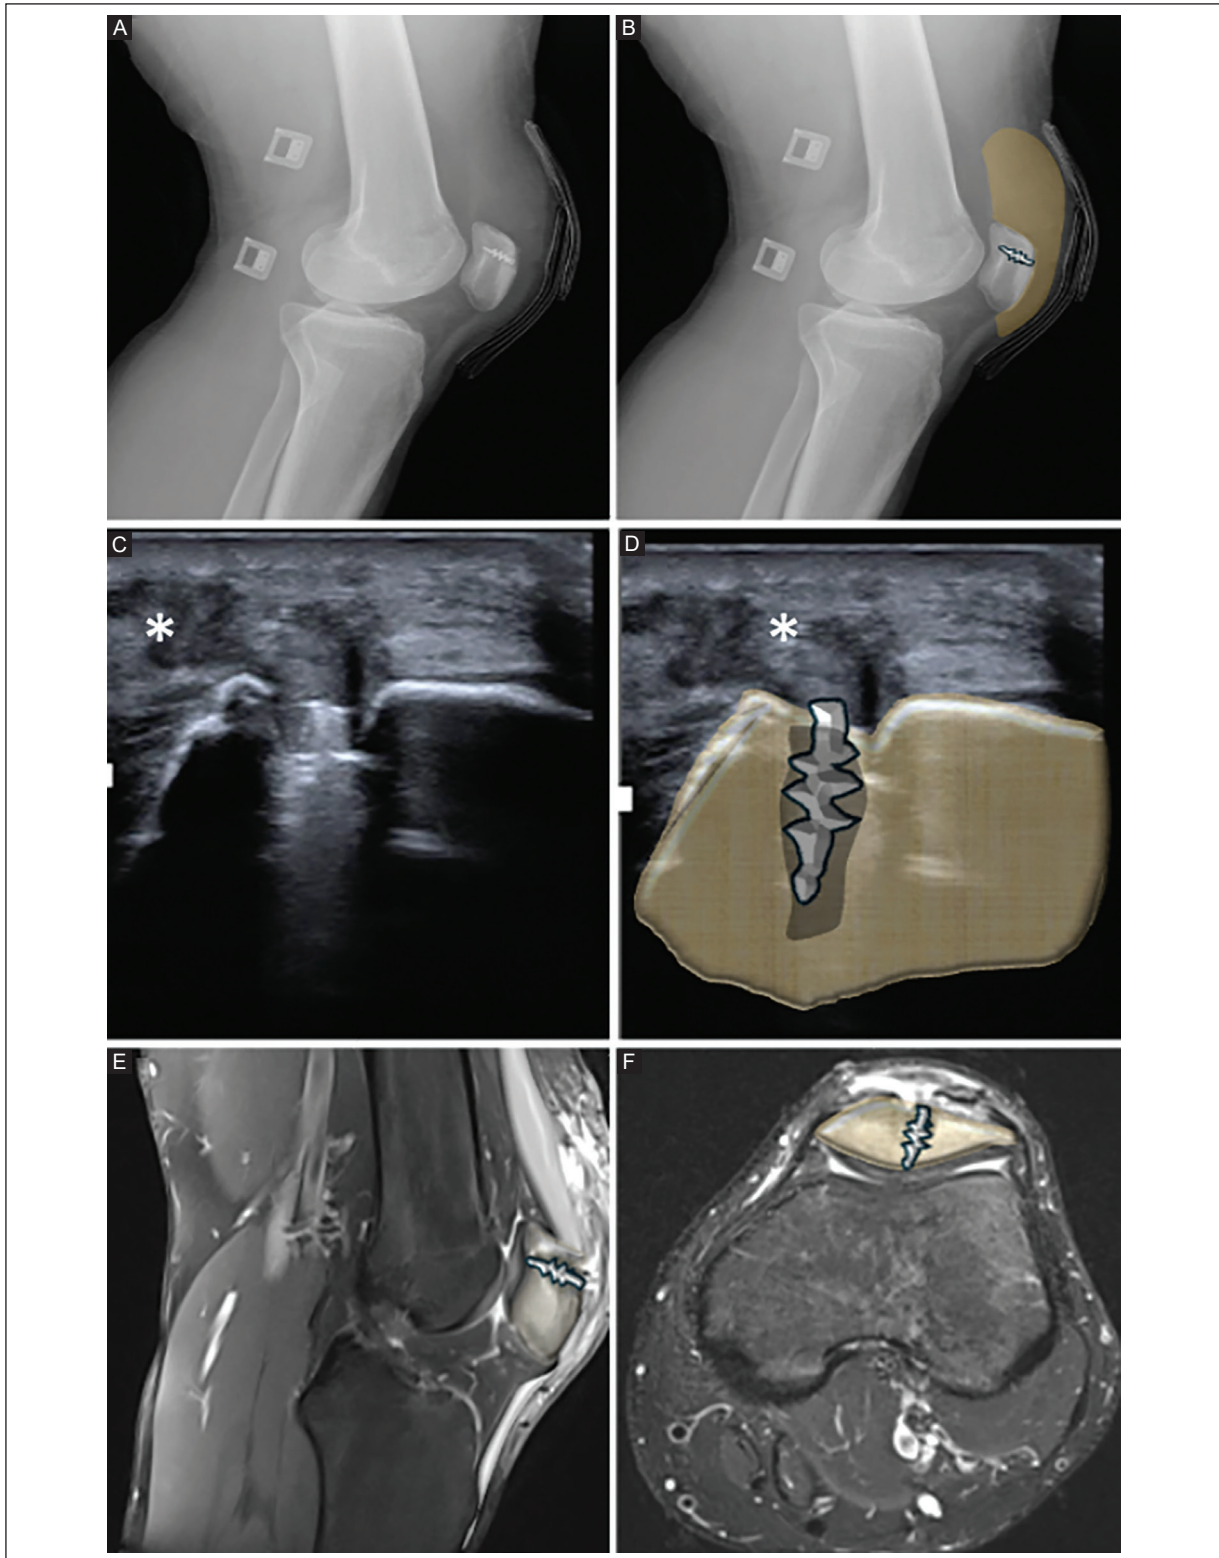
A-B: lateral knee X-rays of a 17-year-old man show the patella with a surgical tendon anchor system and anterior soft-tissue swelling, highlighted in brown. C-D: longitudinal US of the anterior knee shows postoperative soft-tissue edema and fluid collection in the prepatellar bursa (asterisks). The patella is highlighted in brown with the surgical tendon anchor system. E-F: sagittal and axial proton density-weighted MRI with fat suppression shows postoperative anterior soft-tissue edema, characterized by heterogeneous signal in the prepatellar soft tissues with hyperintense fluid distension of the superficial prepatellar bursa. The patella is highlighted in brown. Findings are consistent with postsurgical superficial prepatellar bursitis following a patellar procedure.
